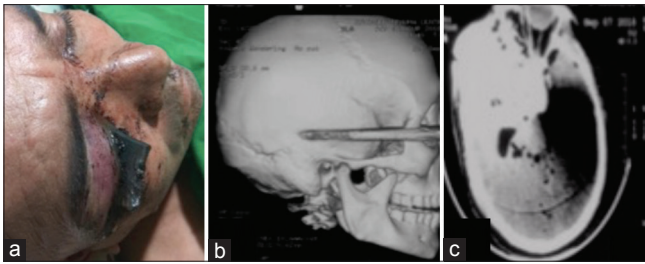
(a) Metallic rod penetrating the right orbit; (b) preoperative X-ray showing object penetrating from the right eye with intracranial extension; and (c) plain computed tomography scan head showing object extending up to posterior clinoid process and the artifact caused by the metal
